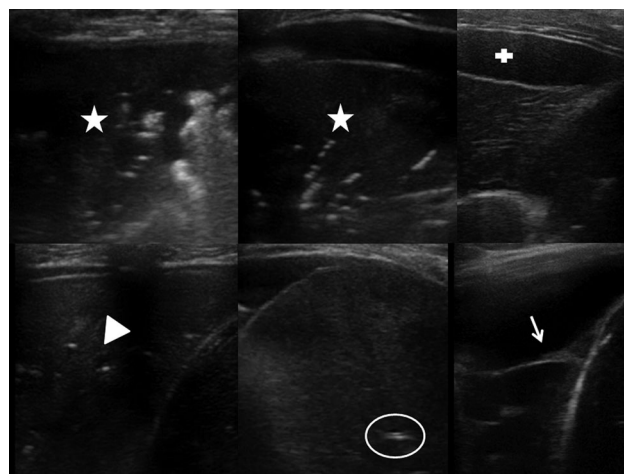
Main lung ultrasound characteristics evaluated. Arboriform, air bronchogram (white star). Punctiform/linear Bronchogram (white triangle). Deep (far from the pleura) liquid bronchogram (anaechogenic binary bronchogram not getting colored with doppler) (white circle). Simple (white cross) and complex (white arrow) pleural effusion with septae
